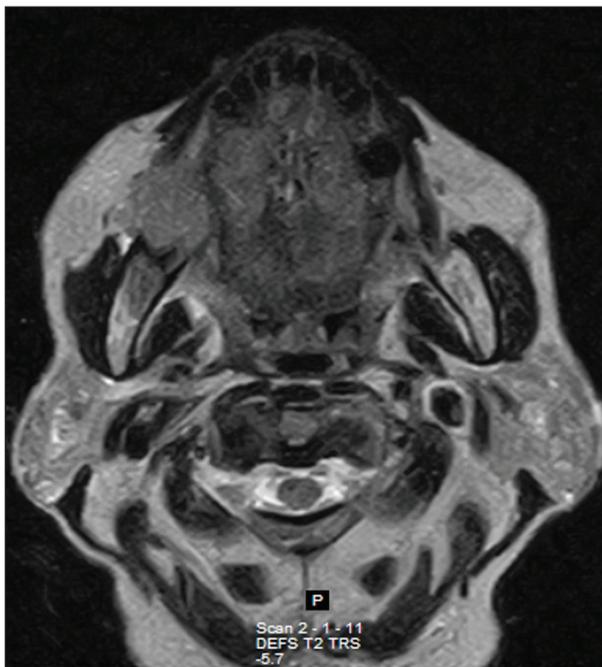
MRI T2w with nodular solid lesion right mandibular inhomogeneously hypointense with lobulated margins.
